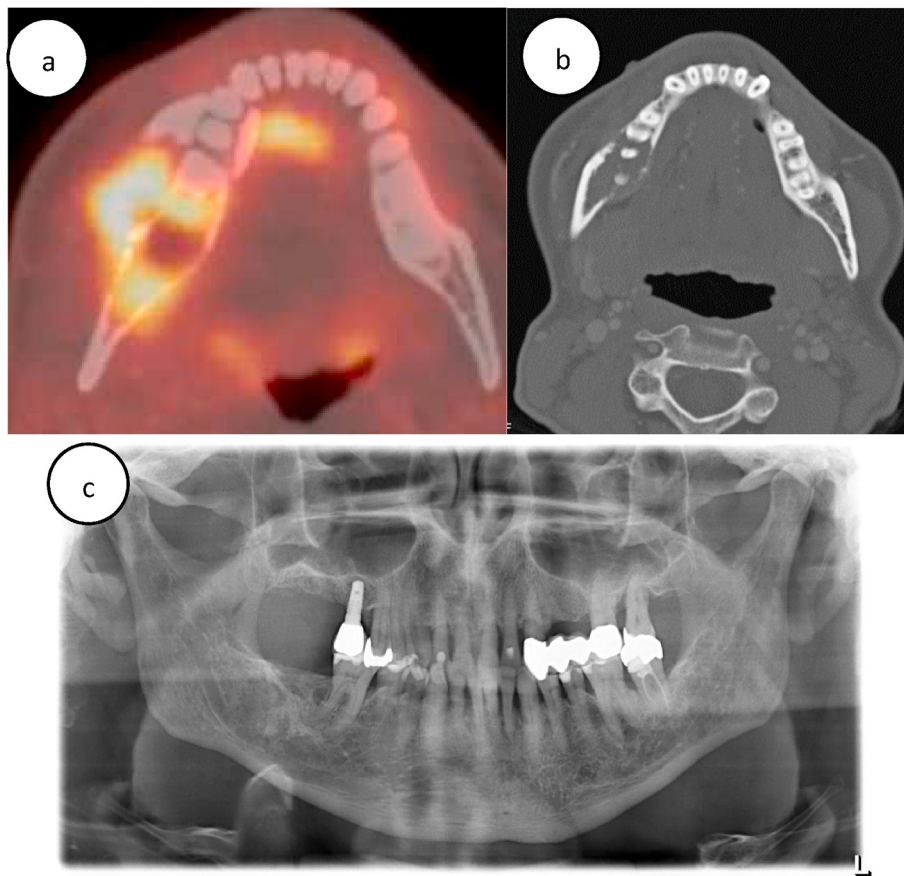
Panoramic radiographic and PET-(FDG)-CT of a 82-year old patient with osteolytic MM lesion of the jaw a) FDG-emission computed tomography of MM lesion of the jaw b) native computed tomography of MM lesion c) Three-year follow up after applying ibandronate.
